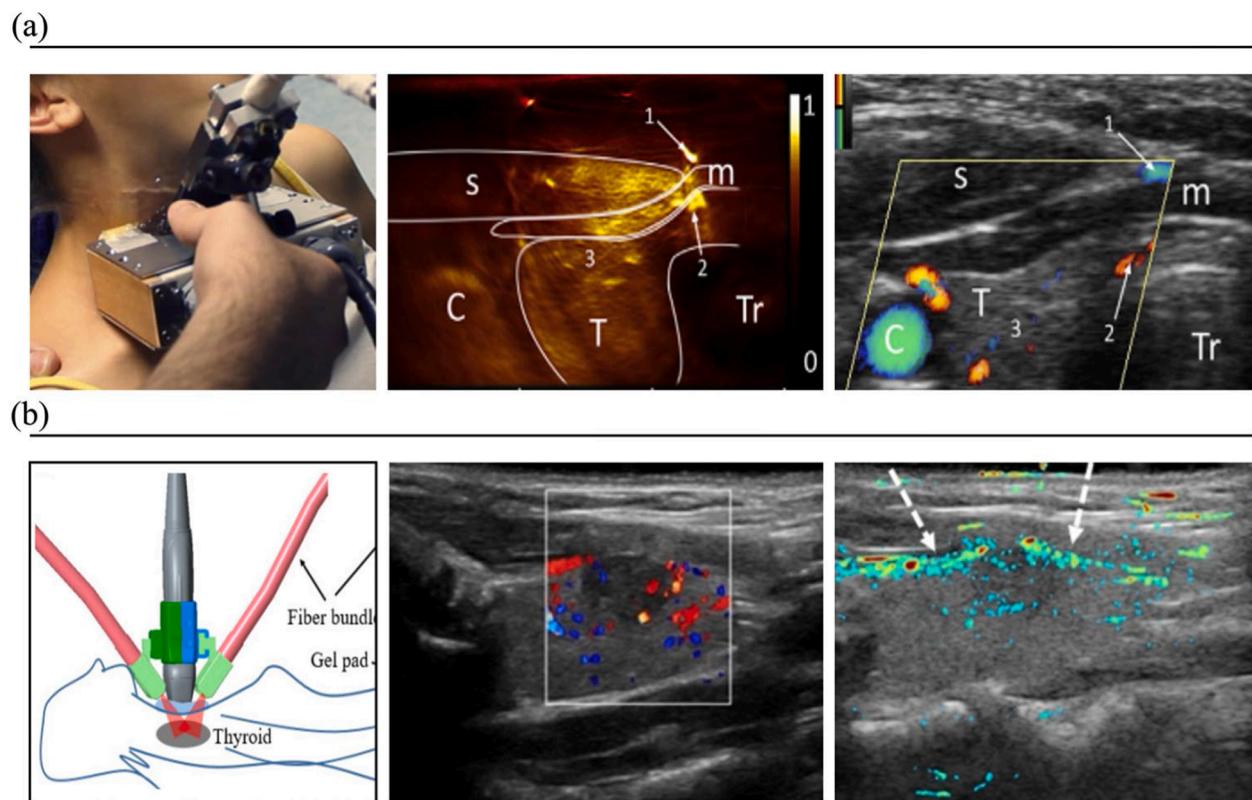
PACT-US for thyroid imaging applications. (a) photoacoustic and ultrasound cross-sections of the left thyroid lobe of a volunteer [84]. (b) photoacoustic and ultrasound results for a left lobe papillary thyroid cancer [85].
